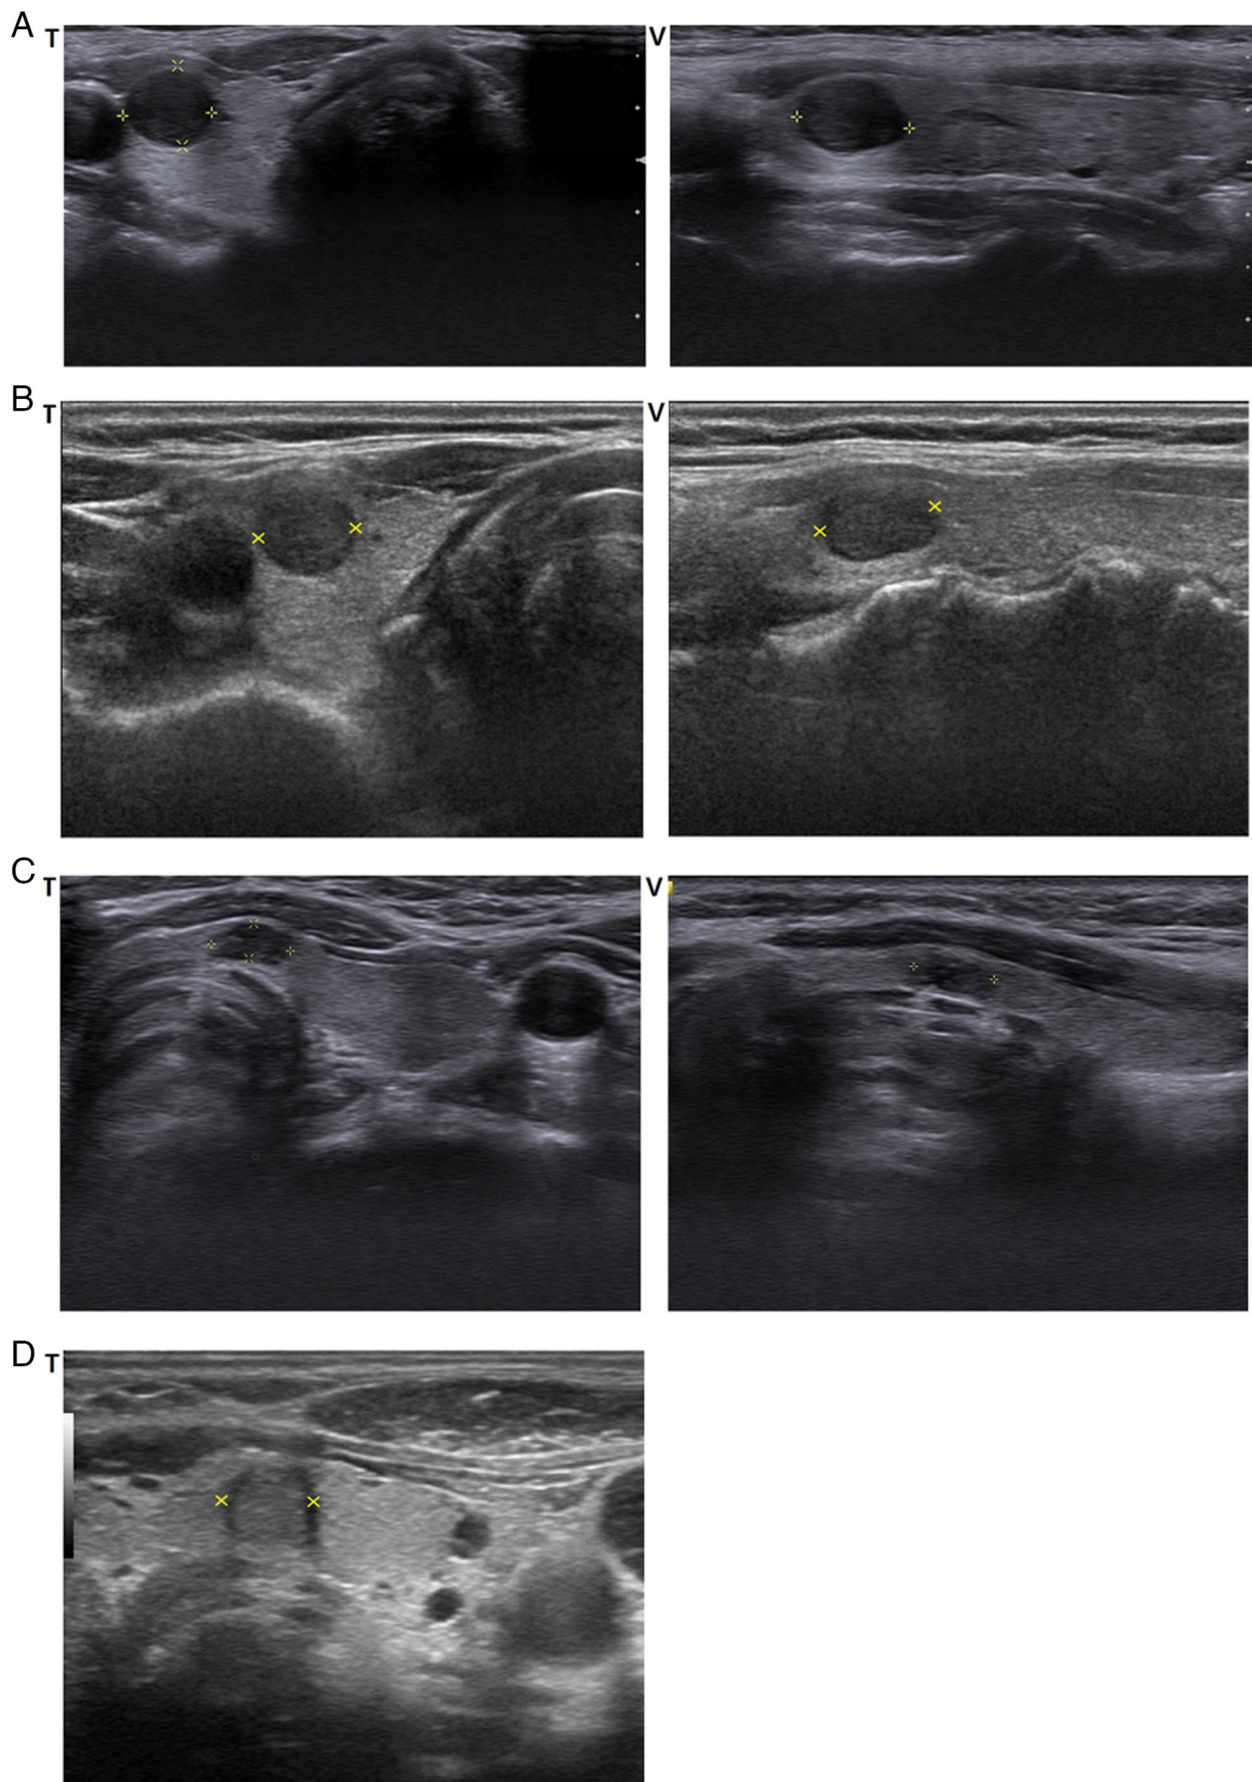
Ultrasonography findings of hyalinizing trabecular tumors. (A) Most tumors (6 cases) appeared as heterogenous hypoechoic lesions with well-defined margins. (B) One tumor appeared as a homogenous hypoechoic lesion with well-defined margins. (C) Three tumors appeared as ill-defined, hypoechoic heterogenous lesions. (D) One tumor appeared as well-defined, heterogenous isoechoic lesion. The yellow crosses indicate the edges of the lesions. T, transverse view; V, vertical view.
